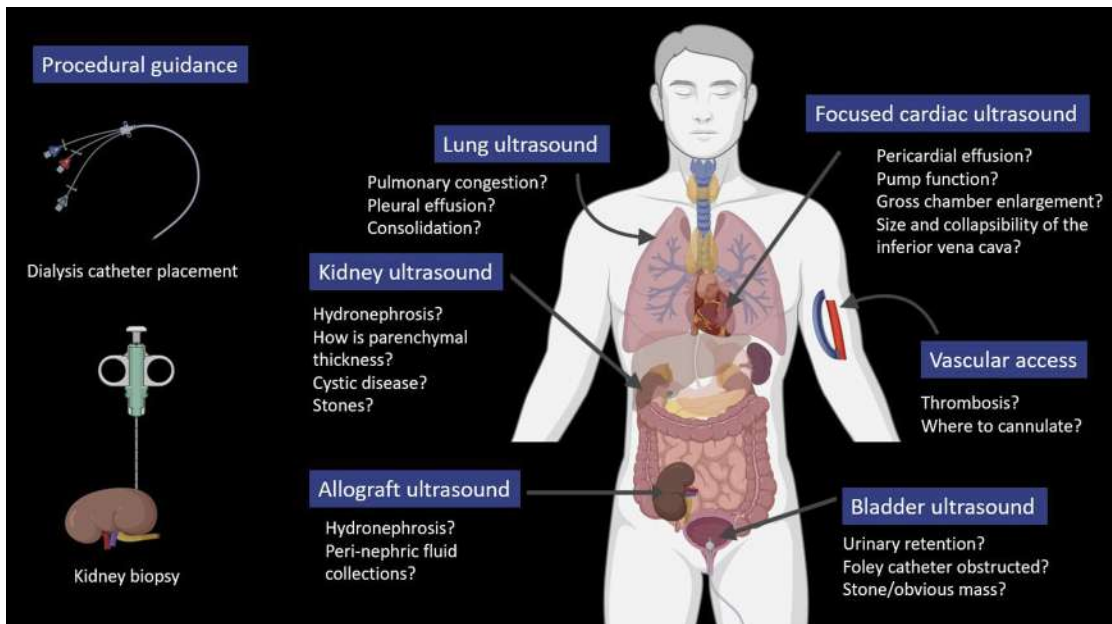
Basic nephrology-related point of care ultrasonography: organs examined and common clinical questions encountered are shown. Created with BioRender.com.
